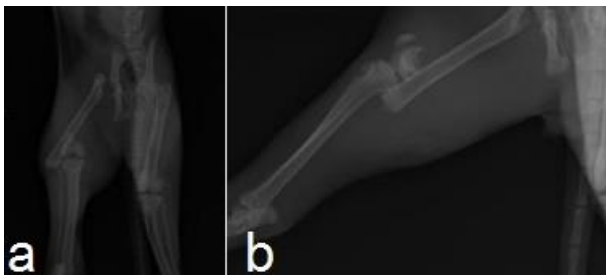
a) Preoperative VD radiograph, b) Preoperative ML radiograph
